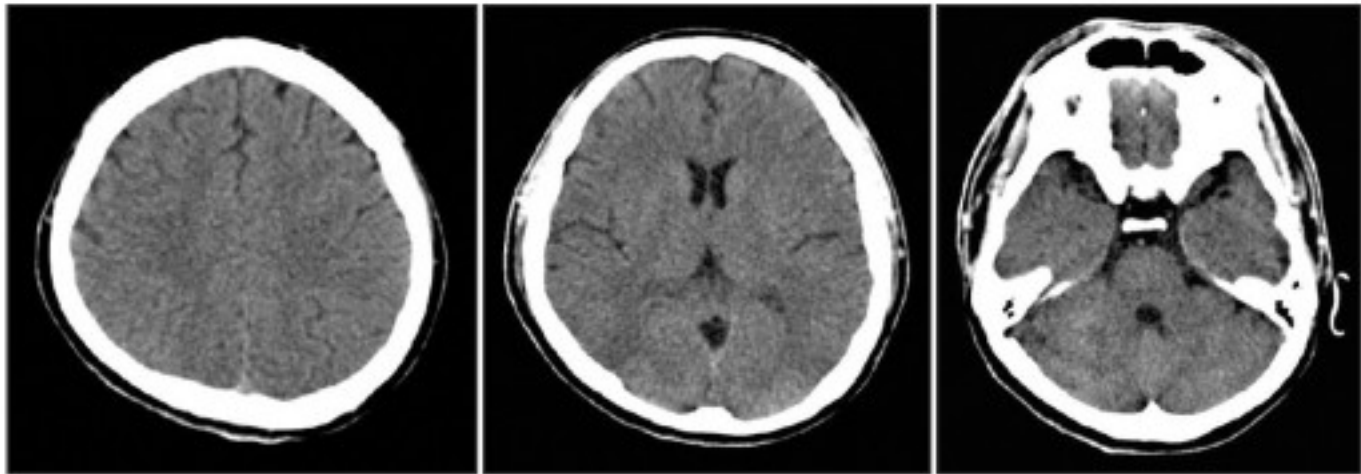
The brain computed tomography scan shows normal findings.
